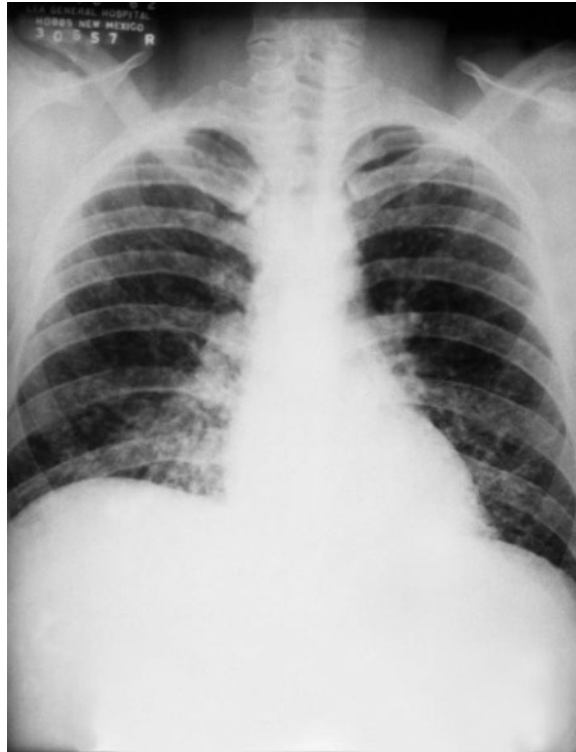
Chest radiograph of a patient with acute pulmonary histoplasmosis. Courtesy of PHIL, CDC.
